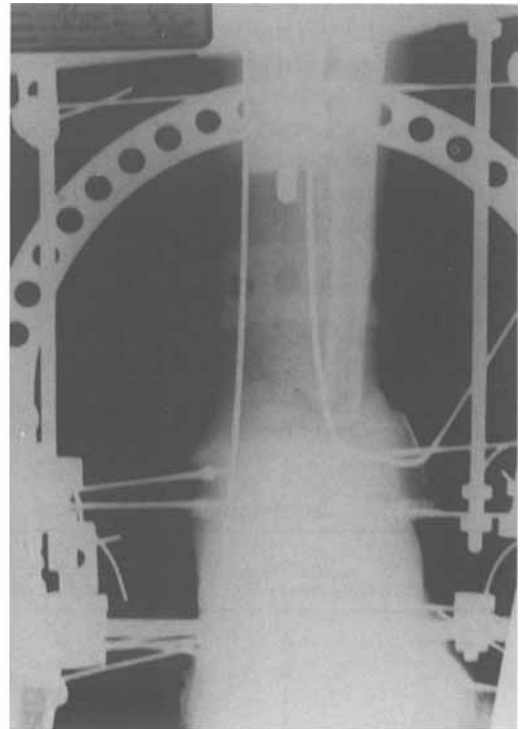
A radiograph of the tibial defect shows alignment before transport.
